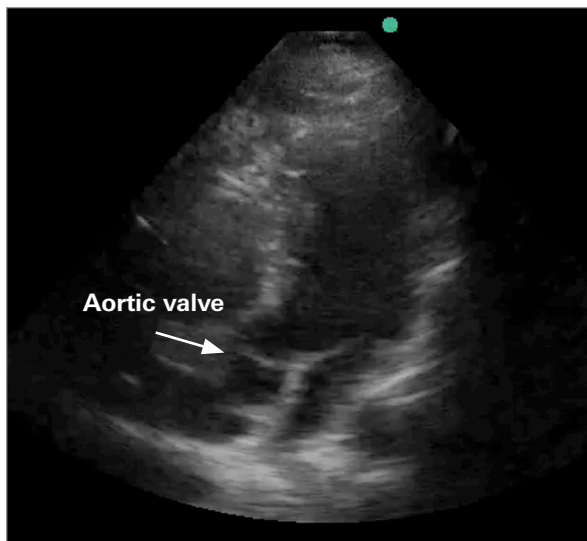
Transthoracic echocardiogram with apical 5-chamber view identifying the aortic valve.
